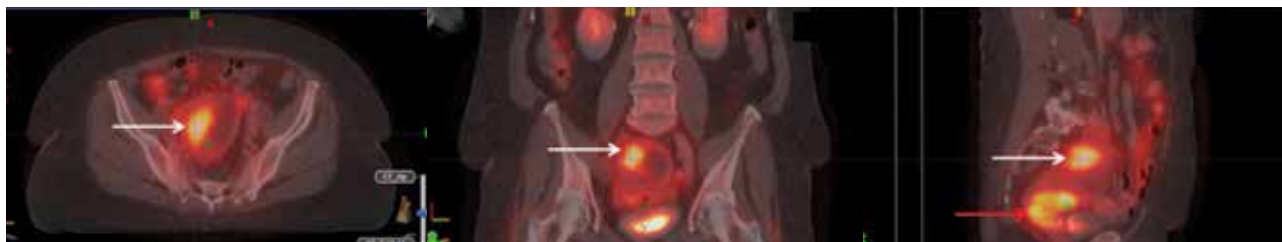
Large primary cervical tumor with extension into the uterine fundus demonstrated on PET/CT as a bi-lobed mass, with a mass in the cervix (red arrow) and a mass in the uterine fundus (white arrows). No lymph node metastases are identified.
